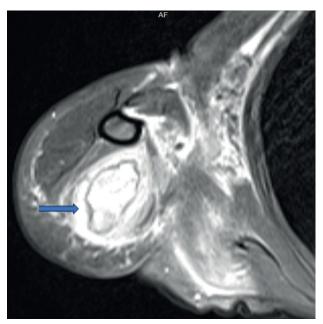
MR image of the hematoma
